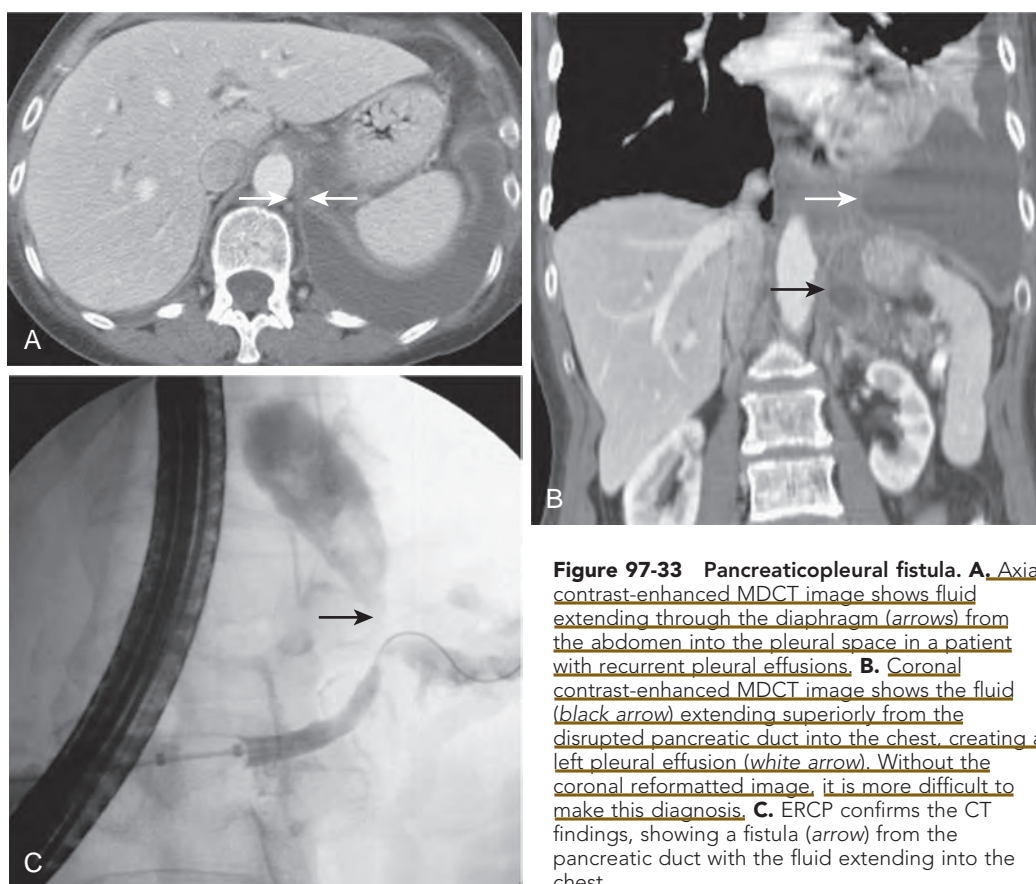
Pancreaticopleural fistula. A. Axial contrast-enhanced MDCT image shows fluid extending through the diaphragm (arrows) from the abdomen into the pleural space in a patient with recurrent pleural effusions. B. Coronal contrast-enhanced MDCT image shows the fluid (black arrow) extending superiorly from the disrupted pancreatic duct into the chest, creating a left pleural effusion (white arrow). Without the coronal reformatted image, it is more difficult to make this diagnosis. C. ERCP confirms the CT findings, showing a fistula (arrow) from the pancreatic duct with the fluid extending into the chest.
